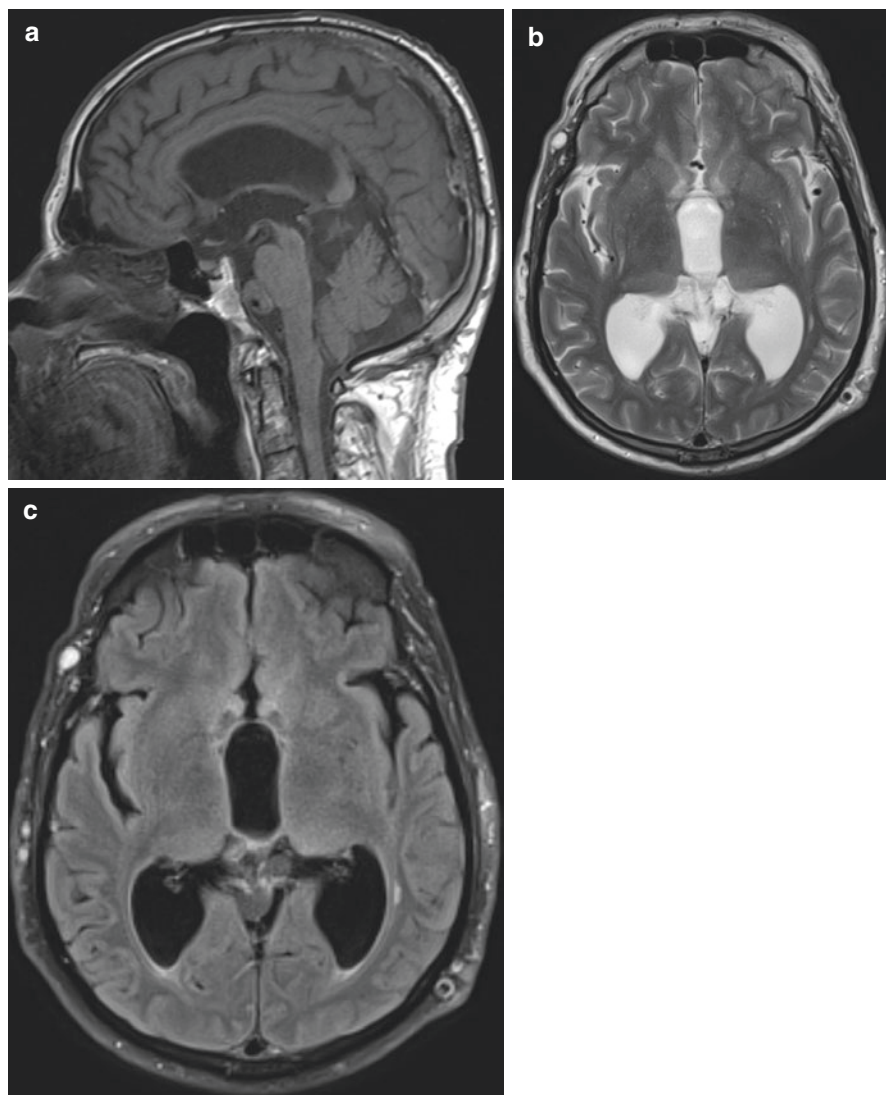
Pilocytic astrocytoma in TIWI (a), T2WI (b), and FLAIR (c) MRI sequences
